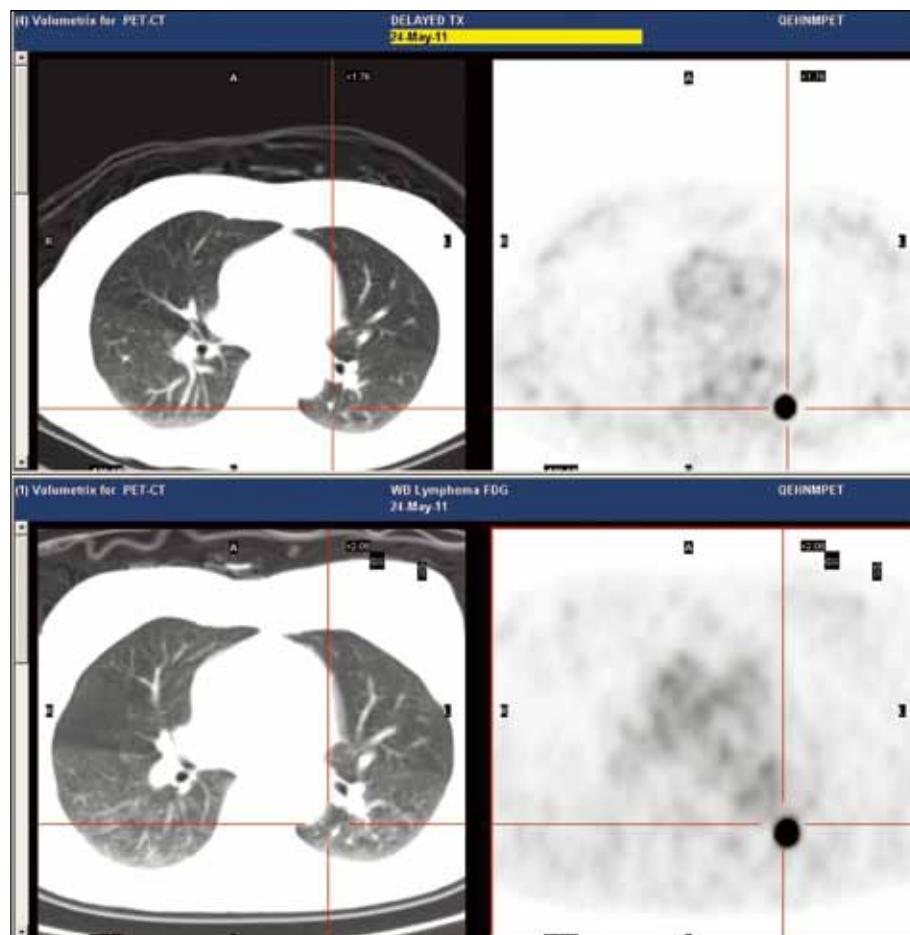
The markedly ^{18}F -fluorodeoxyglucose-avid pulmonary focus at the superior segment of the left lower lobe remains static in position in delayed thoracic positron-emission tomography/computed tomography (upper image) and shows a slight interval increase in maximum standardised uptake value of up to 50.0. There was no corresponding computed tomography abnormality.
